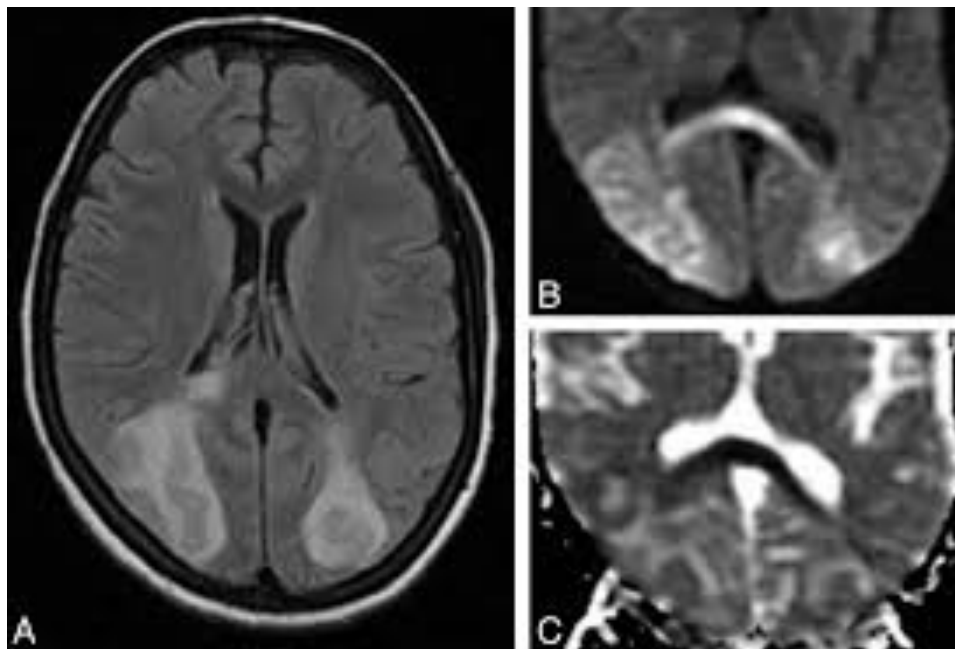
MRI of eclamptic encephalopathy
